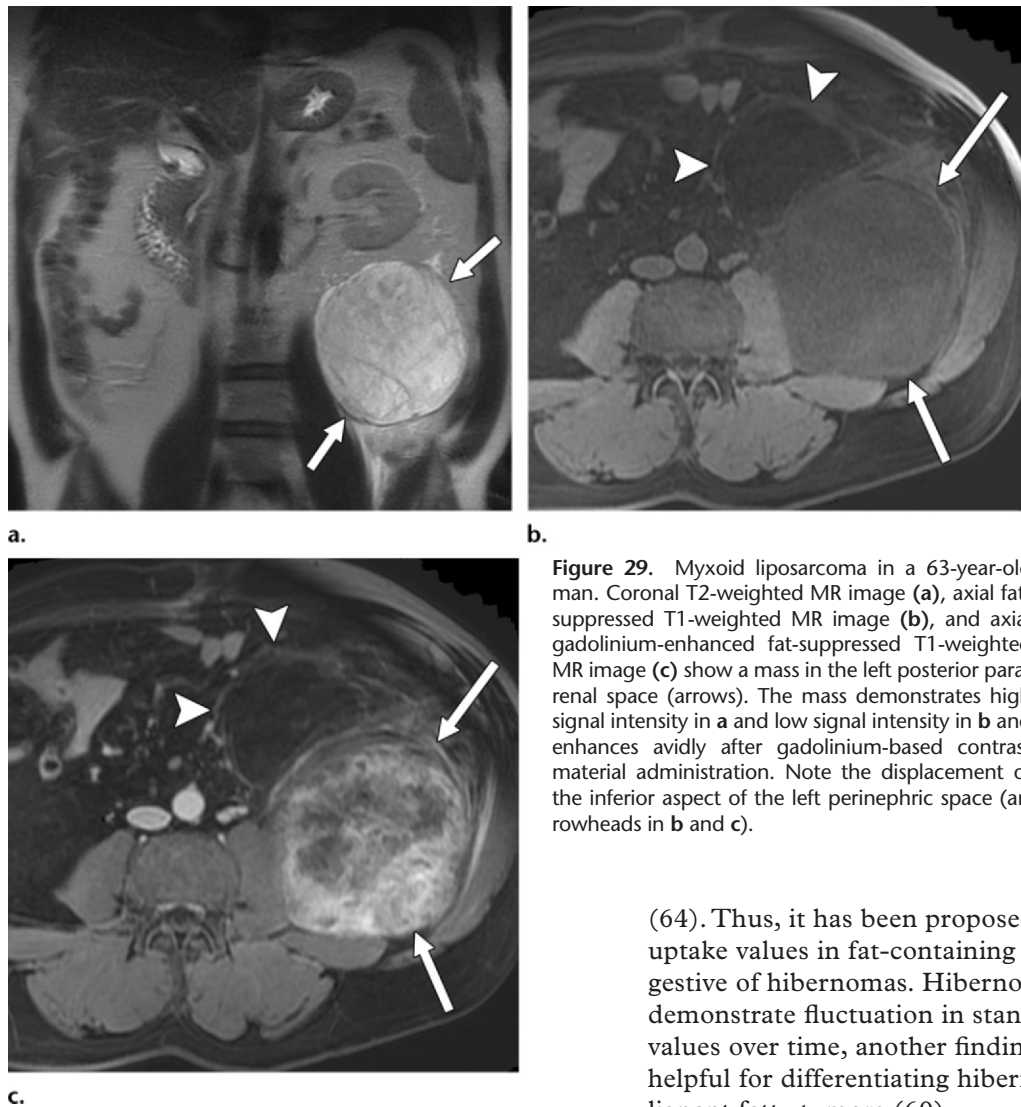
Myxoid liposarcoma in a 63-year-old man. Coronal T2-weighted MR image (a), axial fat-suppressed T1-weighted MR image (b), and axial gadolinium-enhanced fat-suppressed T1-weighted MR image (c) show a mass in the left posterior pararenal space (arrows). The mass demonstrates high signal intensity in a and low signal intensity in b and enhances avidly after gadolinium-based contrast material administration. Note the displacement of the inferior aspect of the left perinephric space (arrowheads in b and c).
